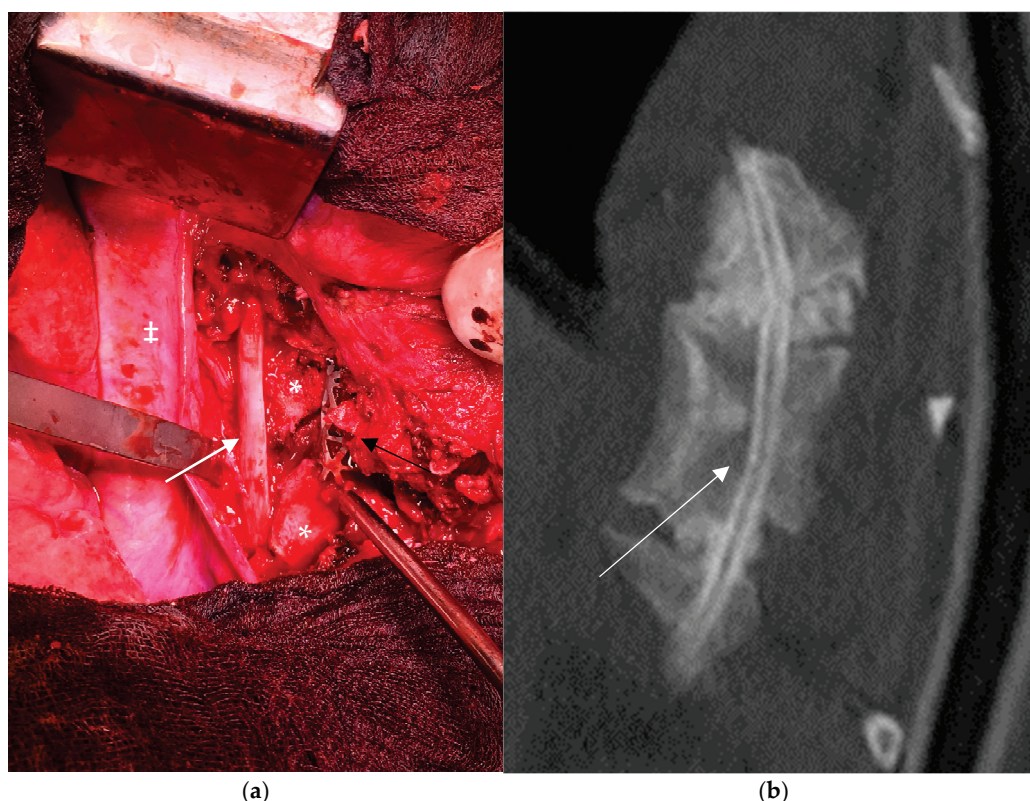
Transthoracic approach to the thoracic spine in a 15-year-old patient with dystrophic scoliosis and kyphotic deformity (a). Anterior strut rib graft (white arrow), anterior vertebral body support with an intercorporeal mesh cage (black arrow), vertebral bodies (*), aorta (‡); (b) The rib graft (white arrow) in place with a bony fusion confirmed by a thin-slice CT scan.
